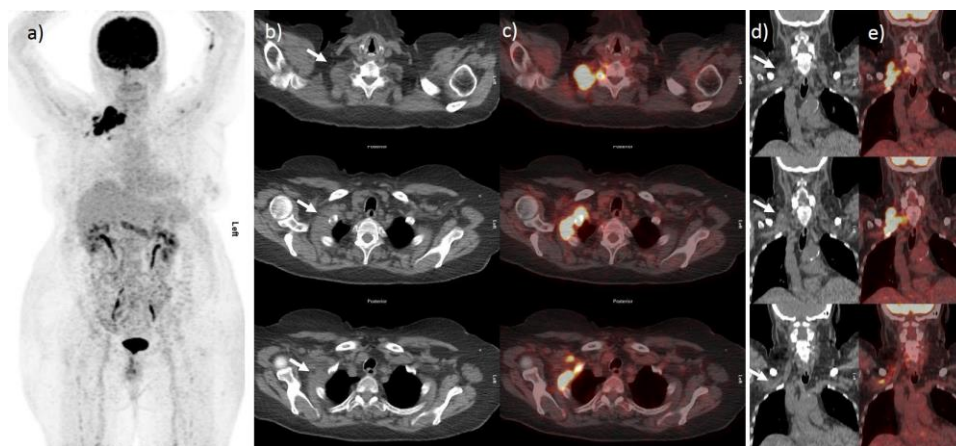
¹⁸F-FDG PET/CT scan of a 54 years old female diagnosed with chronic lymphocytic leukemia in February 2016. Where in a) represents MIP, b-c) CT and fused PET/CT slices, d-e) CT and fused PET/CT slices. The PET scan is showing intense uptake in the corresponding CT lesion (white arrows) in the region of the brachial plexus.
